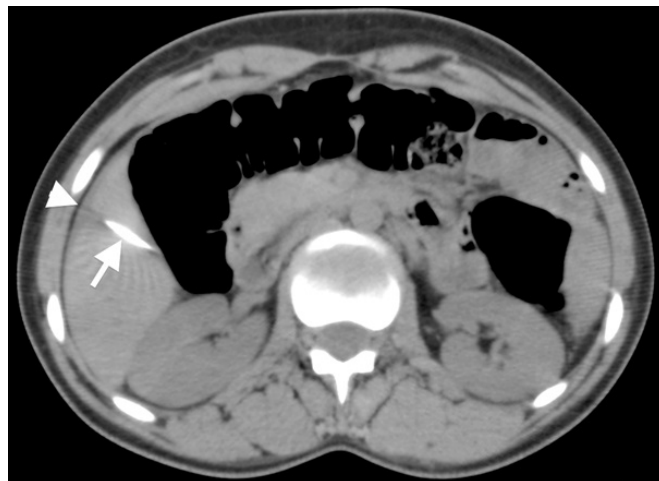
Axial non-contrast computed tomography slice showing a needle passed from the right hepatic flexura and located in the liver parenchyma, and subcapsular bleeding caused by this laceration.
